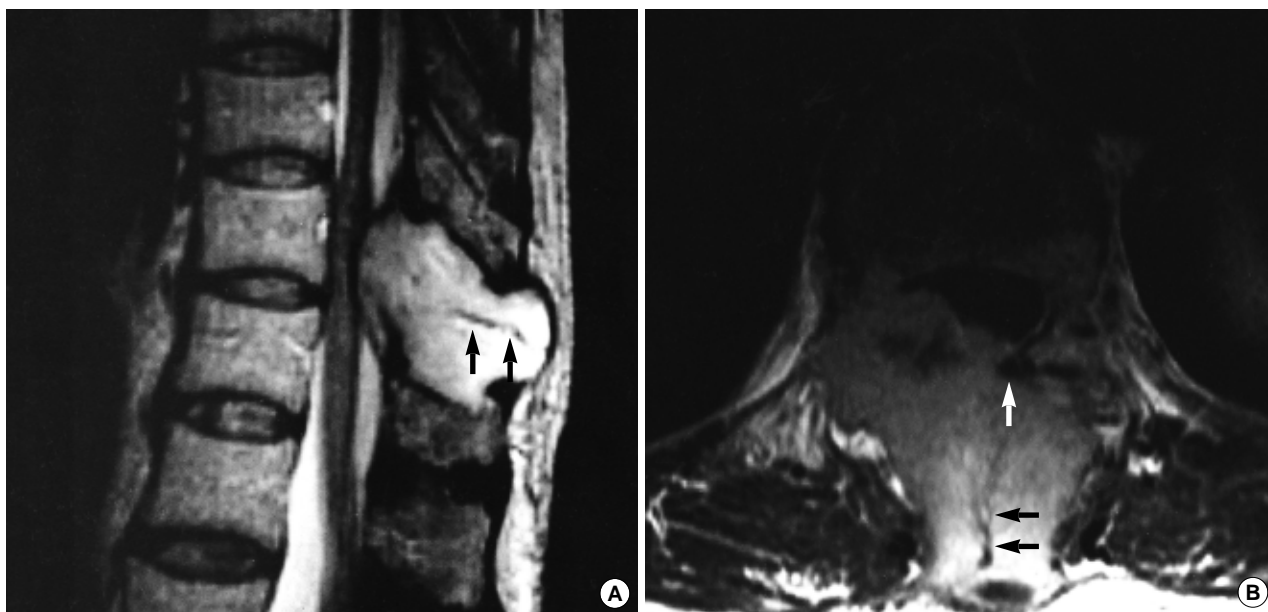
T2-weighted sagittal (A) and Gd-DTPA enhanced axial (B) images show large lobulated mass involving posterior arch of T11 vertebra and posterior epidural mass. The mass is relatively well defined and intense enhancement. There are tree-like tubular and round signal void structures within the lesion (arrows).
